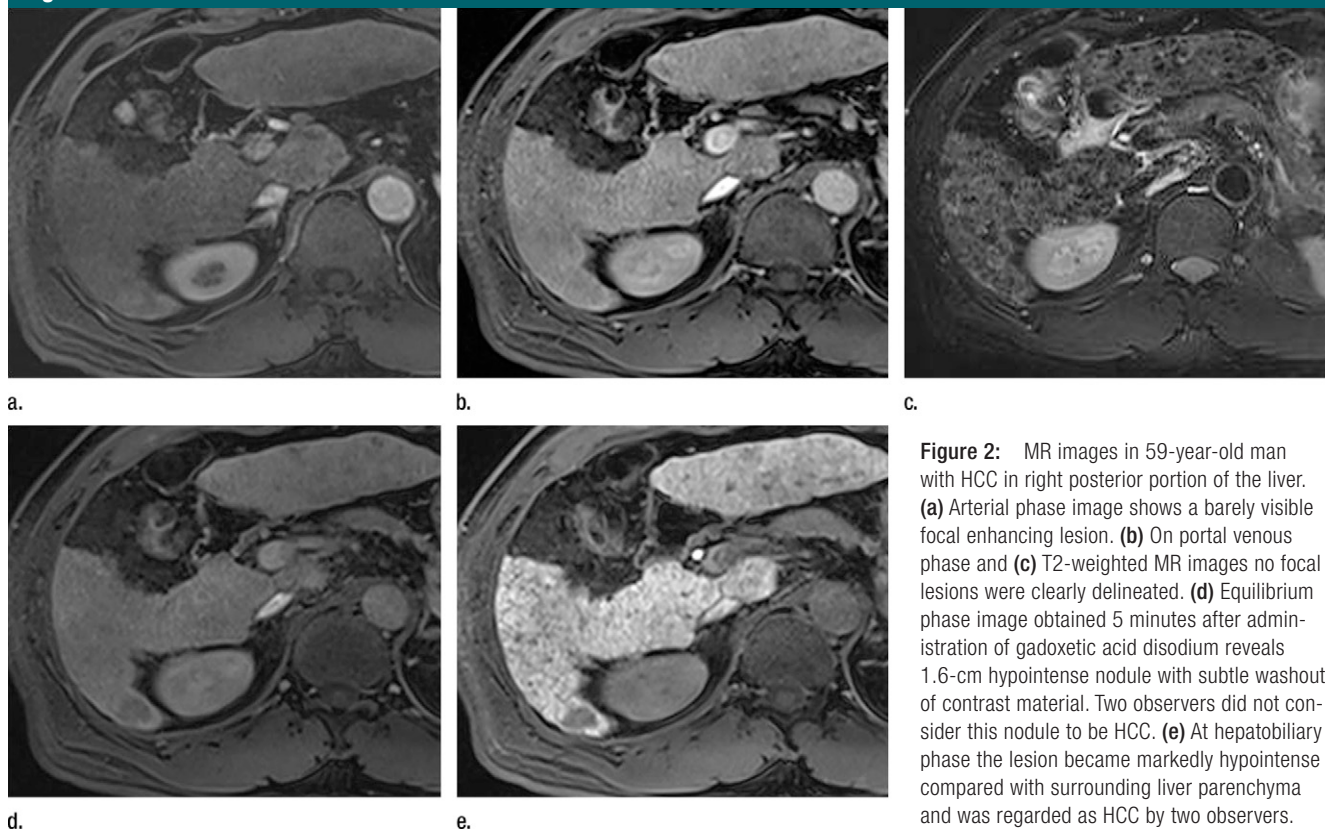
MR images in 59-year-old man with HCC in right posterior portion of the liver. (a) Arterial phase image shows a barely visible focal enhancing lesion. (b) On portal venous phase and (c) T2-weighted MR images no focal lesions were clearly delineated. (d) Equilibrium phase image obtained 5 minutes after administration of gadoxetic acid disodium reveals 1.6-cm hypointense nodule with subtle washout of contrast material. Two observers did not consider this nodule to be HCC. (e) At hepatobiliary phase the lesion became markedly hypointense compared with surrounding liver parenchyma and was regarded as HCC by two observers.
